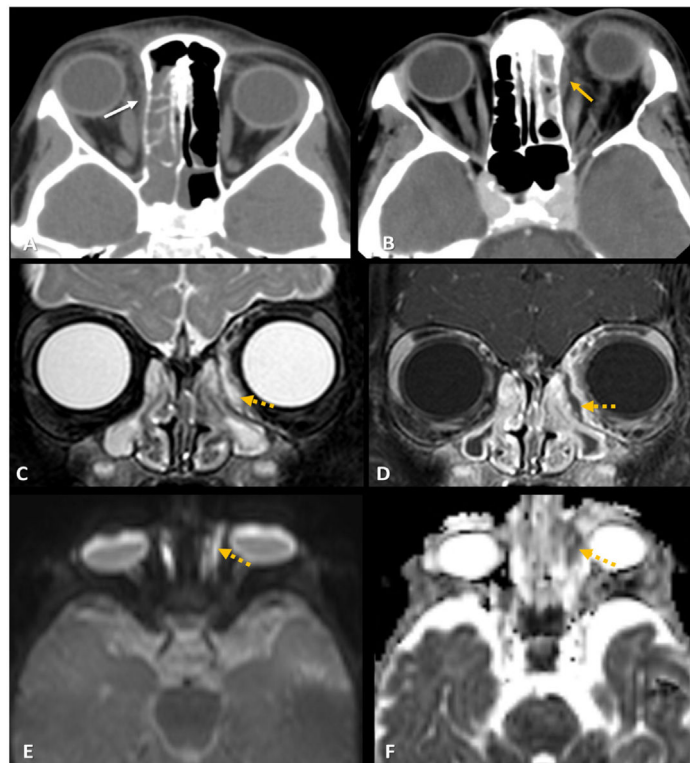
Subperiosteal abscess: (A) Axial non-enhanced CT images, soft tissue window, present opacification of the right ethmoid and sphenoid sinuses, associated to preseptal and orbital cellulitis, with more pronounced fat densification adjacent to the medial orbital wall (white arrows) and irregularity of the lamina papyracea contour, in keeping with early subperiosteal abscess formation. (B) Axial ceCT, soft tissue window, of a different patient shows opacification of the left ethmoidal cells and a conspicuous rim-enhancing crescent-shaped collection (yellow arrows), forming obtuse angles with the adjacent medial orbital wall. Coronal SPAIR (A) and post-contrast fat-saturated T1WI (B), axial DWI (C) and ADC map (D) of another patient show mucosal thickening and filling of the maxillary and ethmoid sinuses bilaterally, associated to a rim-enhancing fluid collection (dotted arrows), adjacent to the medial orbital wall, with restricted diffusion, compatible with subperiosteal abscess.
